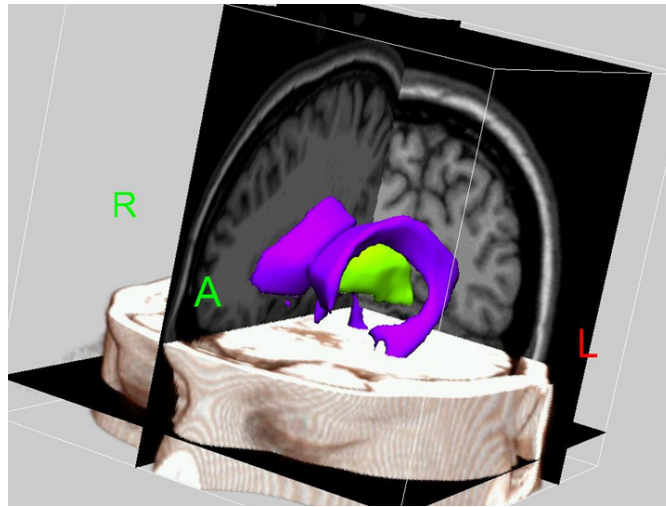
Stereotactic neurosurgery planning and guidance display incorporating surface rendering (Corpus callosum, thalamus), texture-mapped (original MRI data on orthogonal planes) and volume rendered (head surface) data in the same image.
